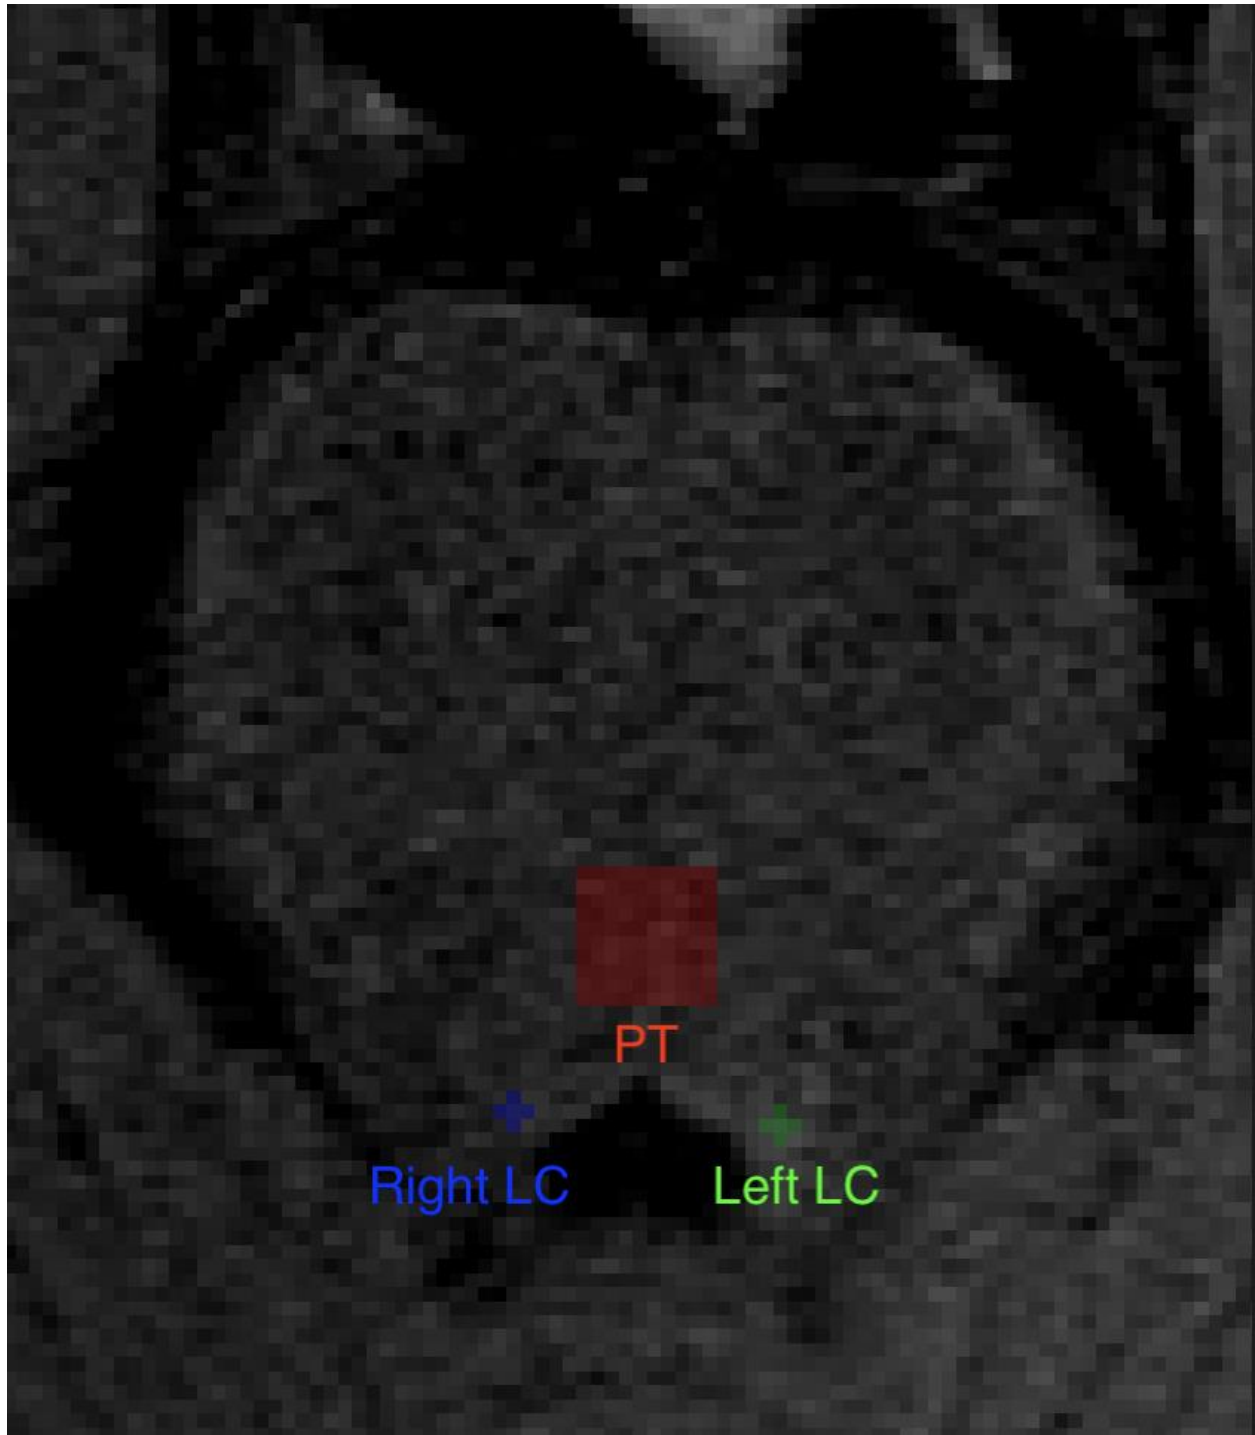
Axial view of neuromelanin-sensitive MRI image and contrast masks for the left and right Locus Coeruleus, as well as the reference Pontine Tegmentum section
